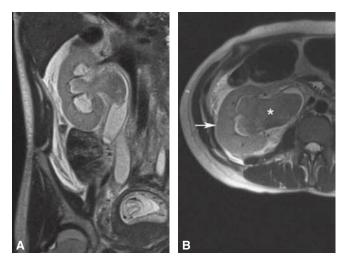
A. Magnetic resonance image in a coronal plane of a pregnant woman with unilateral hydronephrosis caused by ureteral obstruction. The serum creatinine was 8 mg/dL and decreased to 0.8 mg/dL after a percutaneous nephrostomy tube was placed. B. Left kidney (*arrow*) and associated hydronephrosis (*asterisk*) are again noted in this axial plane image.
